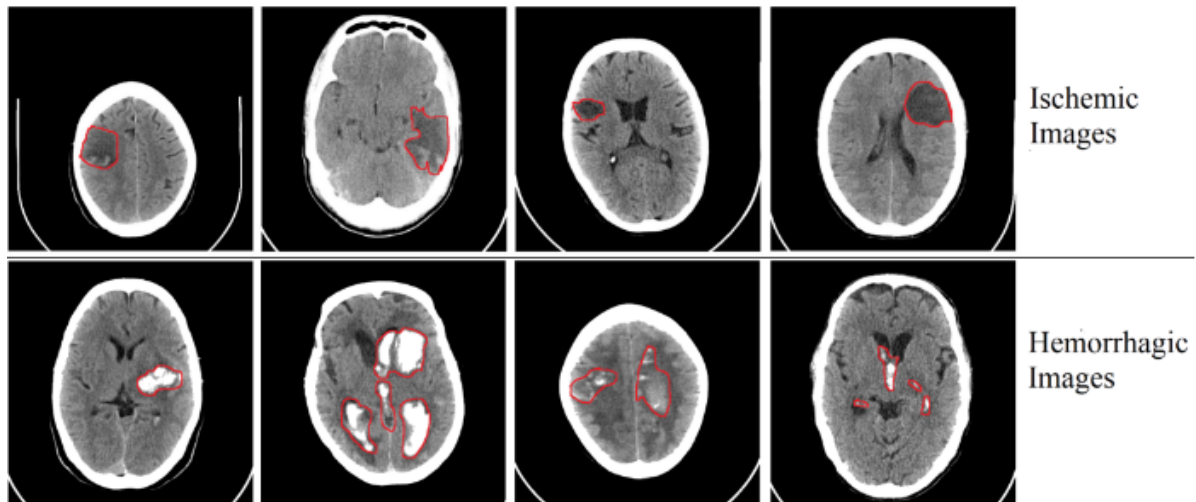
Samples of CT slices to depict the infarcts arising from *Ischemic* and *Hemorrhagic* strokes.
